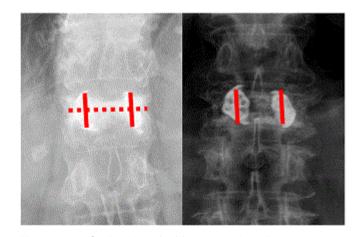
Left: Positive double cross sign. Bone cement not only expand vertically along the bilateral SpineJack system, but also spread across the midline of vertebral body in the AP view of radiographic image. Right: Negative double cross sign. Bone
